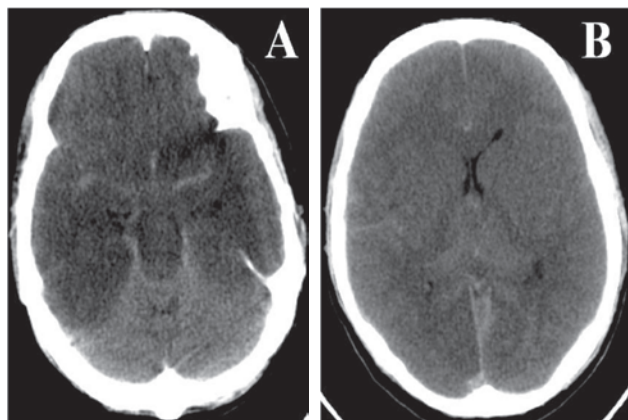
A & B: Non-contrast CT brain scans consistent with diffuse sub-arachnoid haemorrhage, with effacement of the sulci and lateral ventricles, consistent with cerebral oedema. Note the loss of grey-white differentiation, sulcal and basal cistern effacement, increased density of falx and Sylvian fissures.
